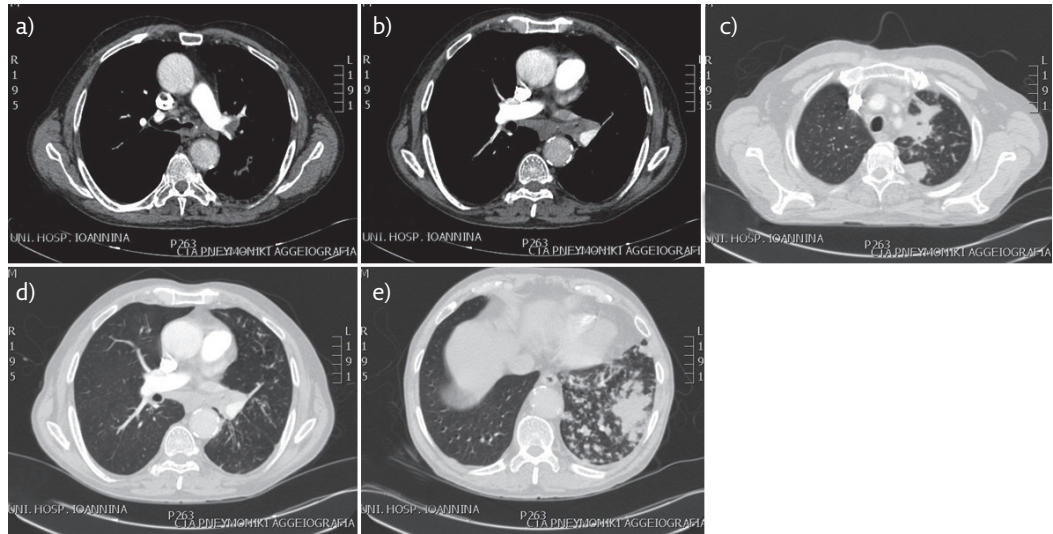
Chest CT. a, b) Obstruction of left main lobe, slightly enlarged mediastinal and left hilar lymph nodes, c-e) lung infiltrates and tree-in-bud opacities in both left upper and lower lobes.
